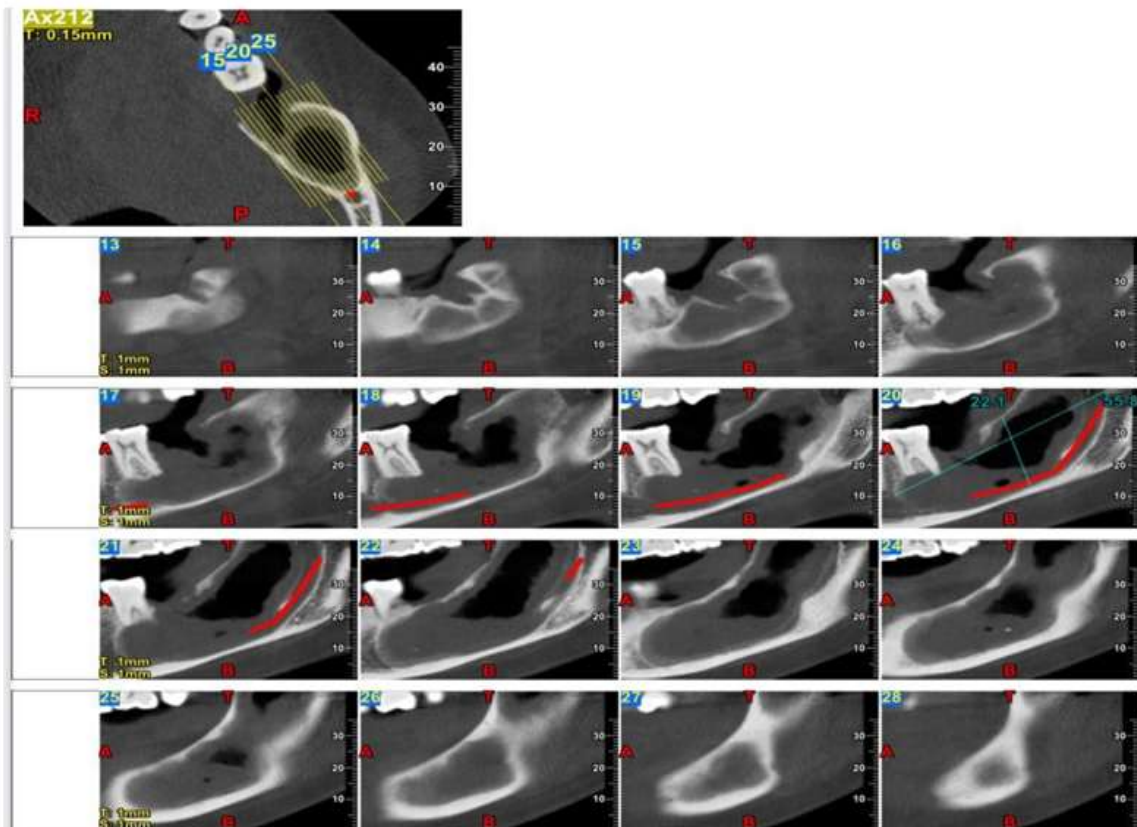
Shows the Conebeam CT Scan (CBCT) of the lower jaw and multiloculated scalloped radiolucent panoramic body and ramus region of the left mandible.
